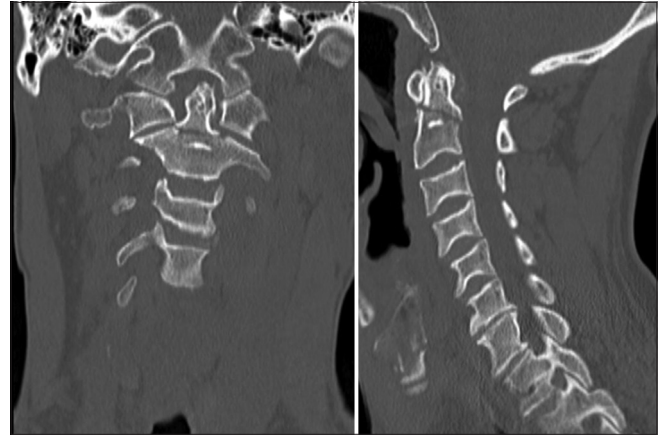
Coronal and sagittal computed tomography images of the cervical spine, demonstrating type II odontoid fracture.
